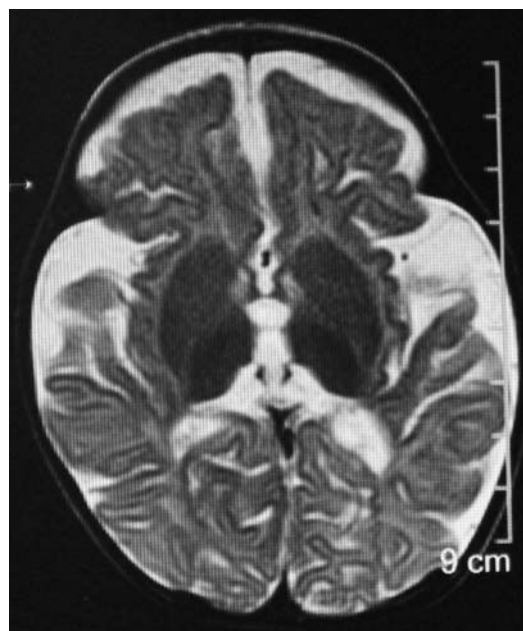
T2W images of MRI brain showing bilateral frontotemporal atrophy with widened sylvian fissures (the bat wings sign) seen in Glutaric Aciduria Type 1.
